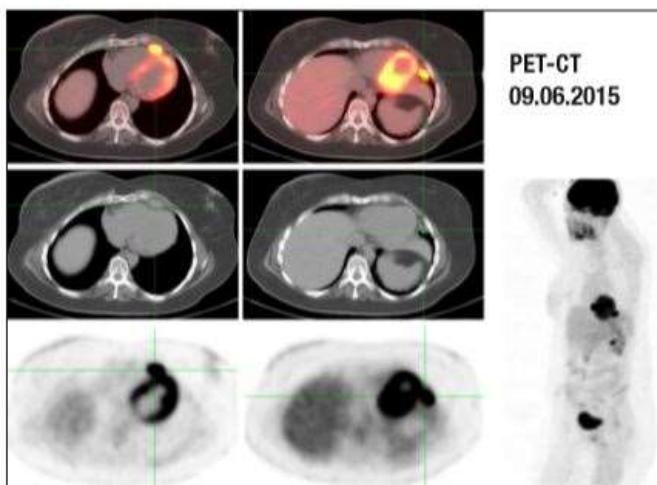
PET-CT-Korrelation mit erstem Tumormarkeranstieg (noch im Normbereich) mit einer kleinen Metastase präkardial und intrathorakal epiphrenisch, beide umgehend per Cyberknife dauerhaft beseitigt.
